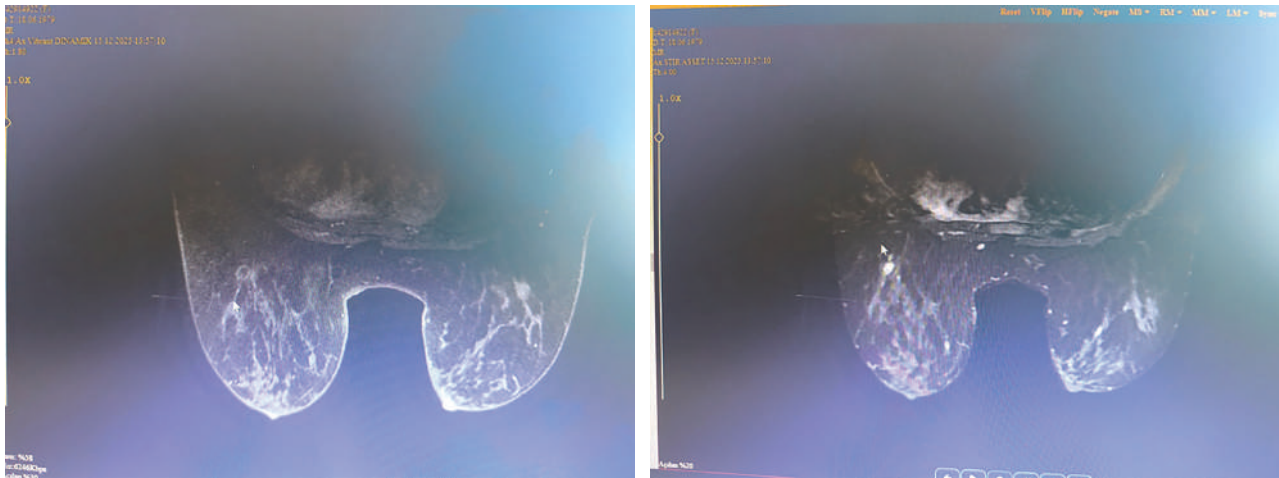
Breast MRI image. Image of a mass visible in the right breast. Breast MRI image dynamic phase.
